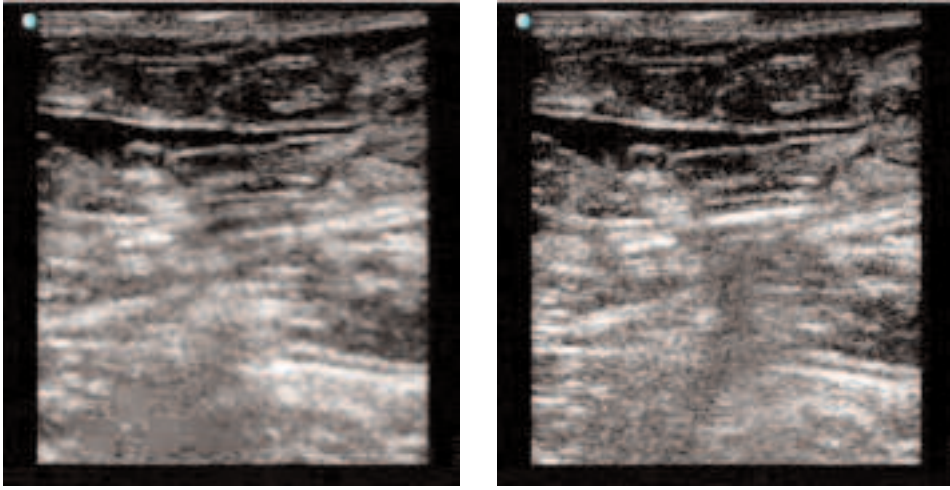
Comparing the left and right ultrasound images captured during laser exposure, the echogenic steam bubbles filling the lumen of the vein over several centimetres can be clearly observed in the right frame.
